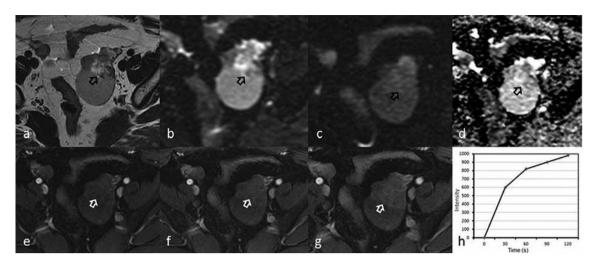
Imaging of a 54-year-old woman affected by malignant Leydig-Sertoli cell tumor (false-negative). a: Axial T2-weighted image showing a hypointense cyst of the left ovary with heterogeneous solid component (arrow). b,c: Axial diffusion-weighted image does not show the presence of high signal of the solid component (arrow in b and c) on b-values of 0 and $1000s/mm^2$ with an apparent diffusion coefficient (ADC) map (d) giving isointensity of solid component (arrow in d) and an ADC value of 1.38×10^{-3} mm²/s. e-g: Axial T1-weighted fat-suppressed images showing slight hyperintensity of the solid component (arrow in e) and its progressive enhancement in the early phase (arrow in f) after administration of gadobenate dimeglumine without wash-out in the late phase (g). h: Time-intensity curve obtained on the solid part of the lesion.
